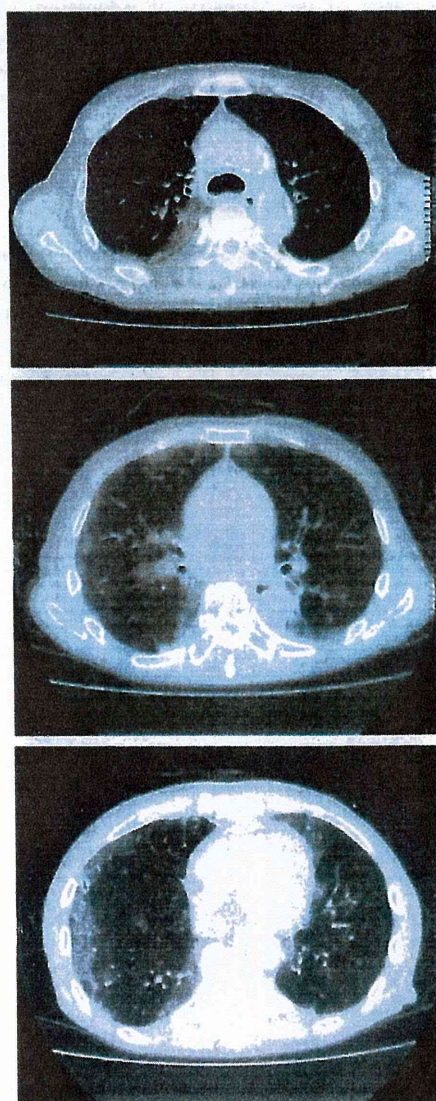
61-year-old male patient with H1N1 pneumonia. HRCT scan of the chest obtained on hospital day 11 showing bilateral and peripheral focal ground-glass opacities in the upper (A), middle (B), and lower (C) zones.
